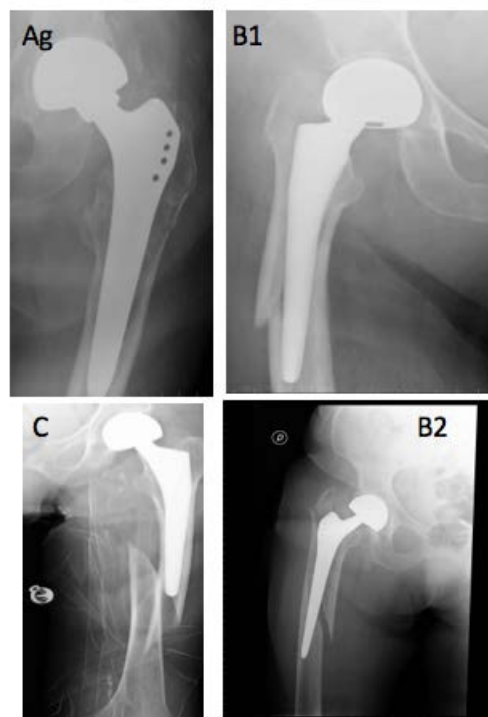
Radiographic images of different periprosthetic fractures occurred in the study population classified according to Vancouver classification.
